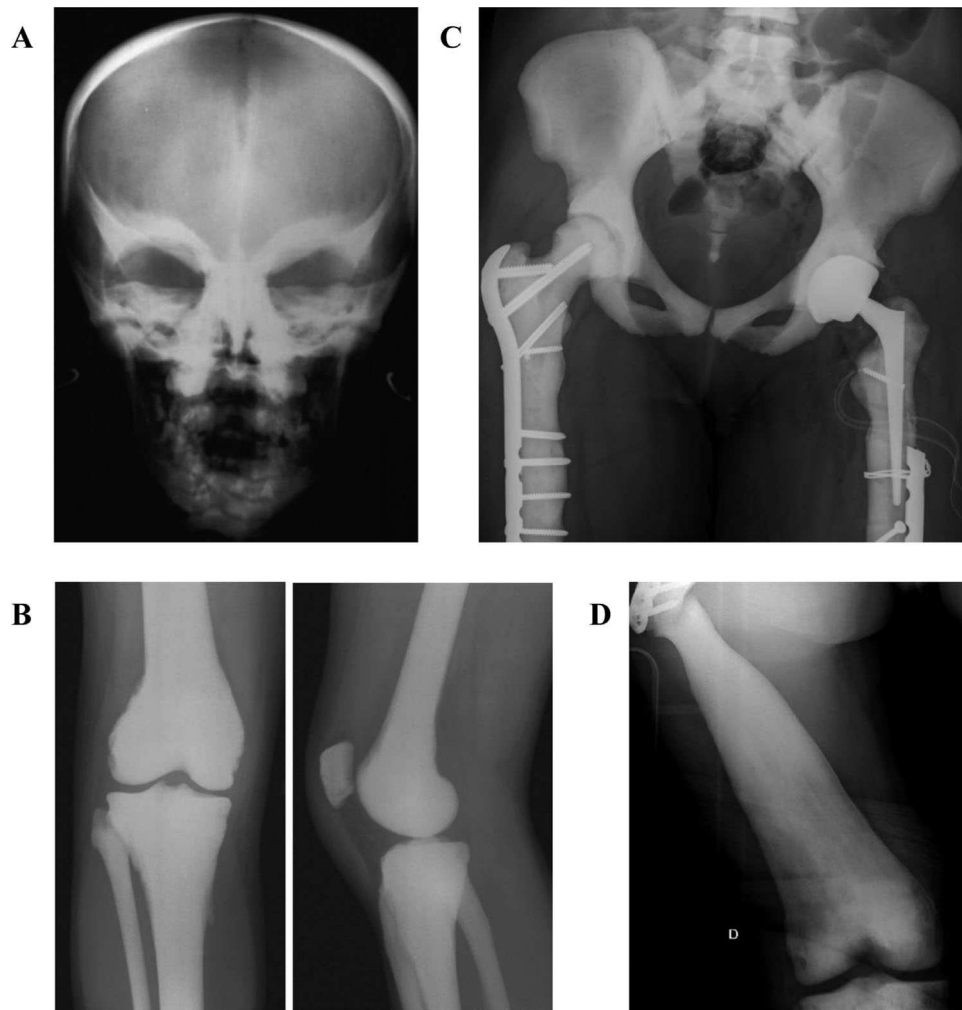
Representative X-rays of Pt 1A, Pt 1B, and Pt 2, showing a diffuse increase in bone density, the typical harlequin-mask pattern of the sclerotic skull base on the AP cranium, the lack of metaphyseal bone remodeling, and the bone deformities resulting from the remodeling defects and the non-perfect healing and remodeling of fractures. (A) Pt 1A at age 6 years; (B) Pt 1B at age 2 years; (C) Pt 1A at age 35 years; (D) Pt 2 at age 22 years. Overall, the radiographs testify for a severe form osteopetrosis.
